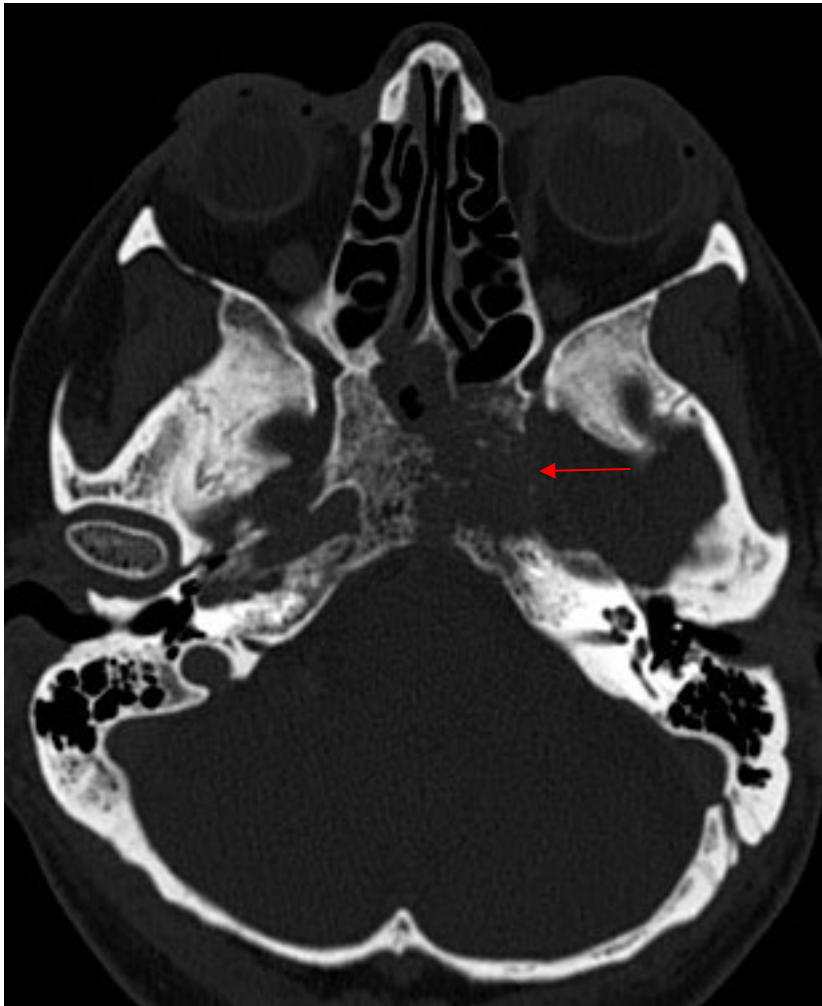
Transaxial CT image showing extensive clival destruction.
